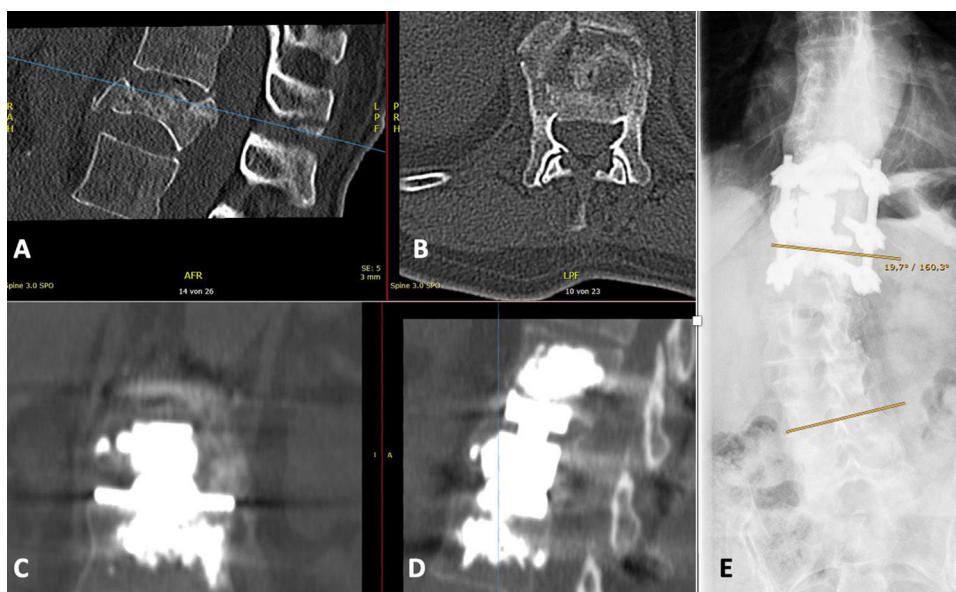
Traumatic Th12 fracture. (A/B) Preoperative CT scan. (C/D) Postoperative CT scan following short segment fixation with cement augmented pedicle screws and VBR with endplate cementation. (E) Stand up X-ray (coronal view) at last follow up. The lumbar scoliosis remained constant. The patient was fully functional and had no restraints in daily activities five years postoperatively.
